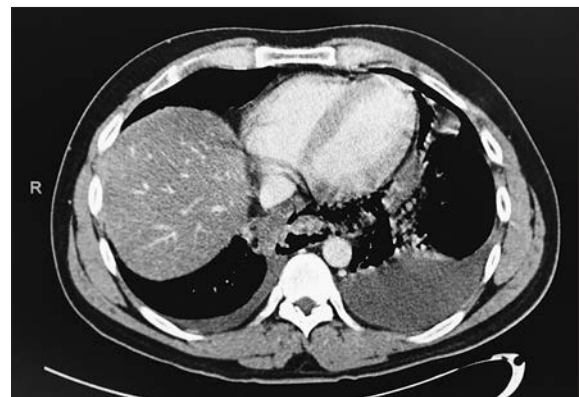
Chest computed tomography scan revealing a lower oesophageal perforation with left-sided moderate and right-sided small pleural effusion with dependent atelectasis associated with heterogeneous pulmonary density, possibly reflecting extensive pneumomediastinum extending into the lower neck.
